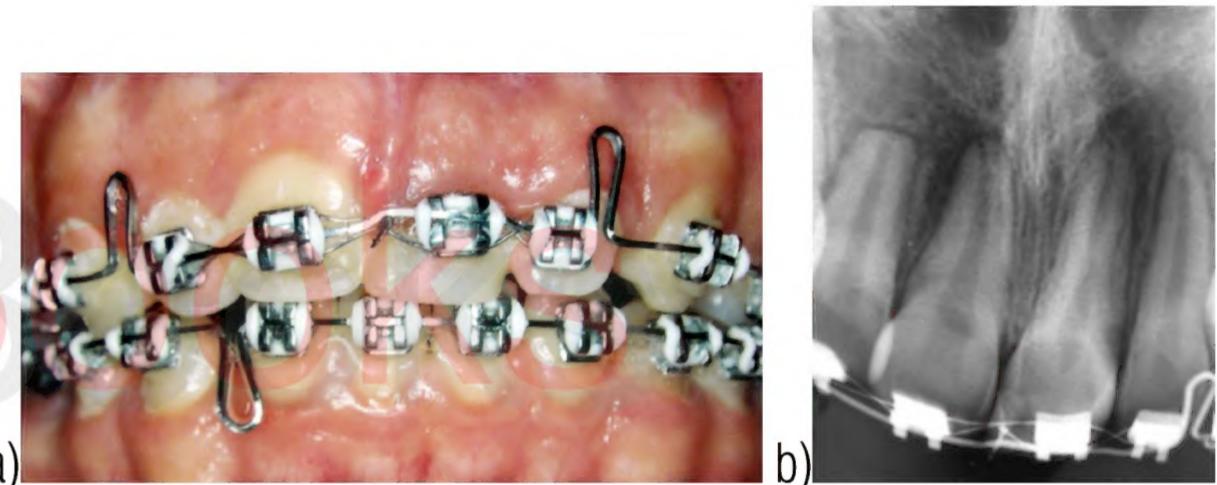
a) Two years follow-up; b) periapical radiograph.
